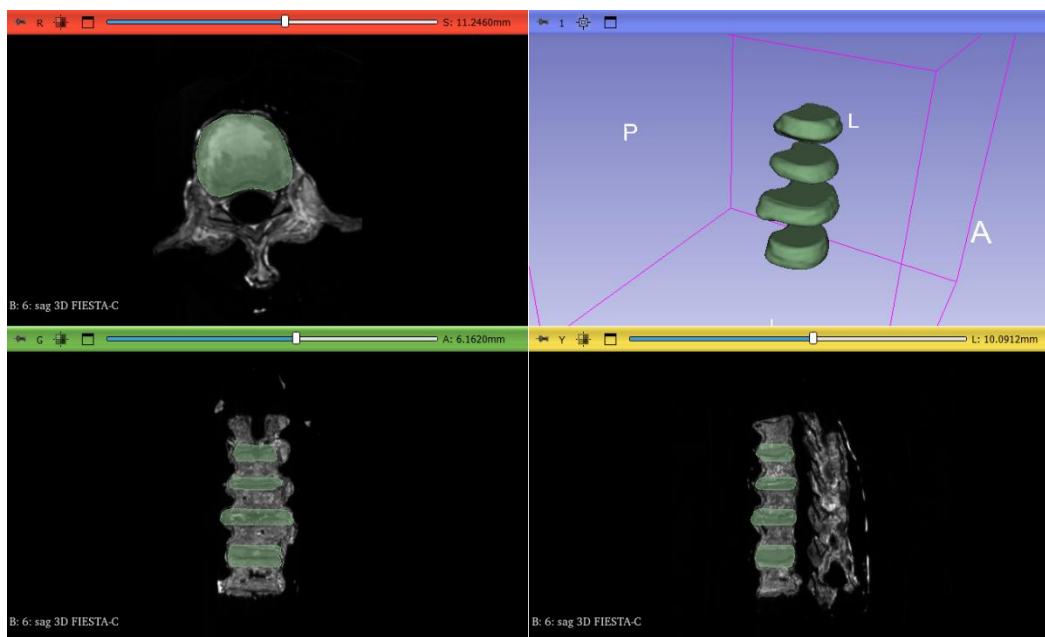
disc segmentation from MRI scans
